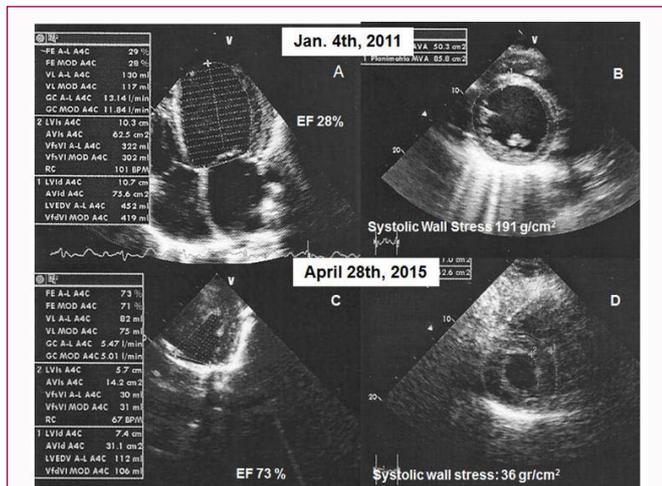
A) Baseline Echocardiogram EF 28%. B) Baseline systolic wall stress 191 g/cm². C) Echocardiogram 3 years after surgery with and EF 73%. D) Systolic wall stress of 36 g/cm² after surgery.
